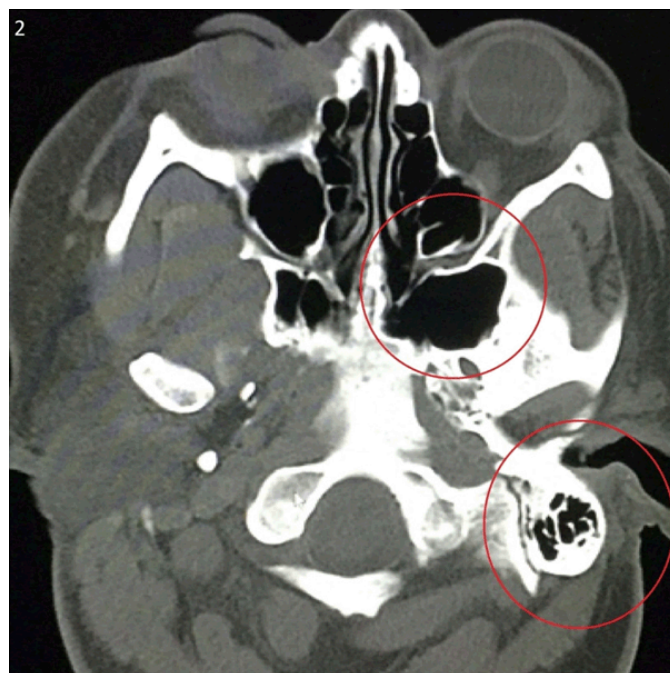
Axial CT scan of brain with contrast revealed asymmetric spheno-ethmoidal recesses, ethmoidal sinuses and prominence of left mastoid air cells (red circles in Figure 2). No evidence of subdural or epidural hematoma noted.
